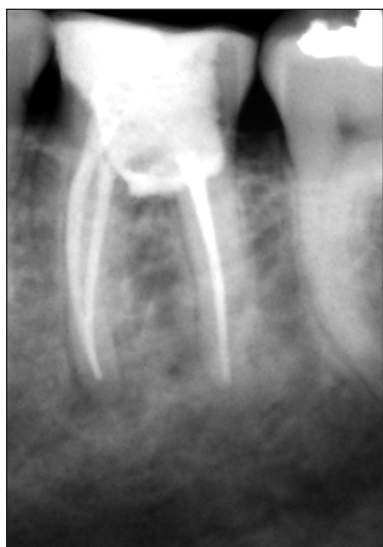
Post-treatment radiograph confirming radio-opaque MTA covering the perforation site.
